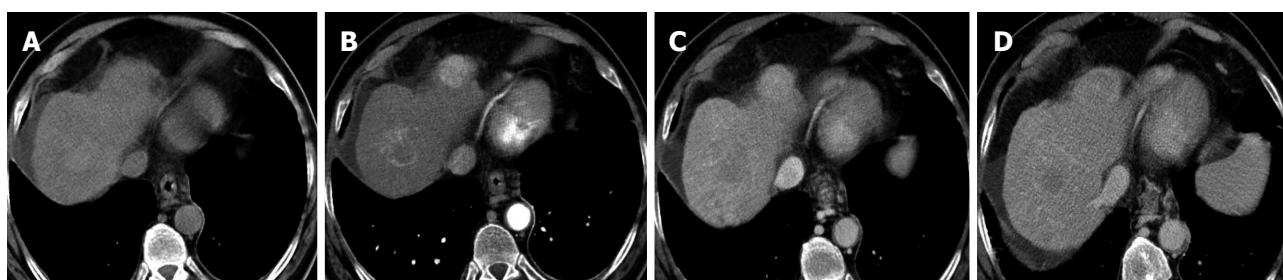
A new typical hepatocellular carcinoma found at computed tomography during follow up another hepatocellular carcinoma treated with radiofrequency ablation (central lesion). Note that also in the treated lesion there is a marginal area of vital hepatocellular carcinoma.
